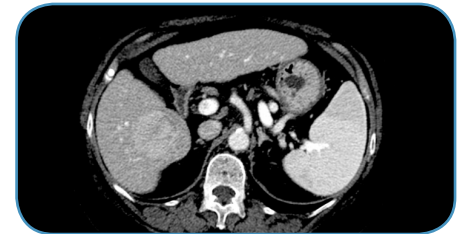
CT image in portal phase of HCC before
